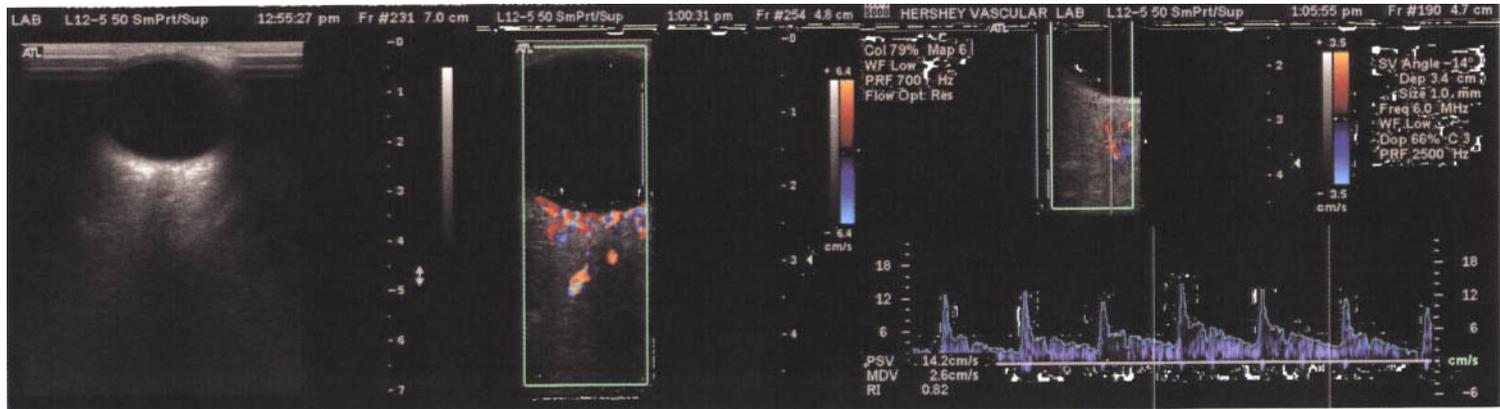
Steps of transorbital examination. B-mode of the eye and optic nerve (left), B-mode plus color Doppler flow (center), angle-corrected velocimetry of the ophthalmic artery (right).
